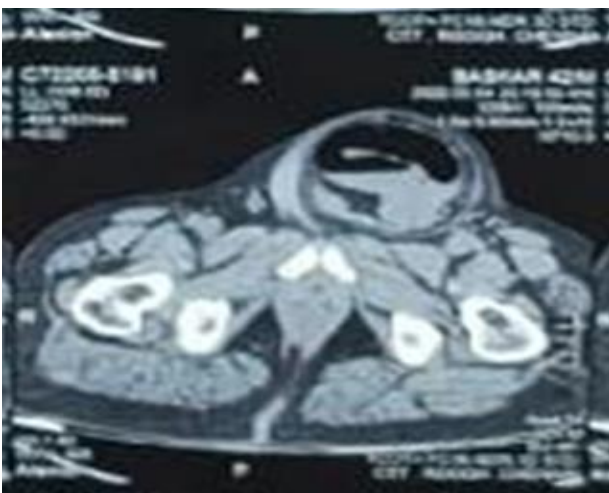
CT Abdomen showing obstructed inguinal hernia.
